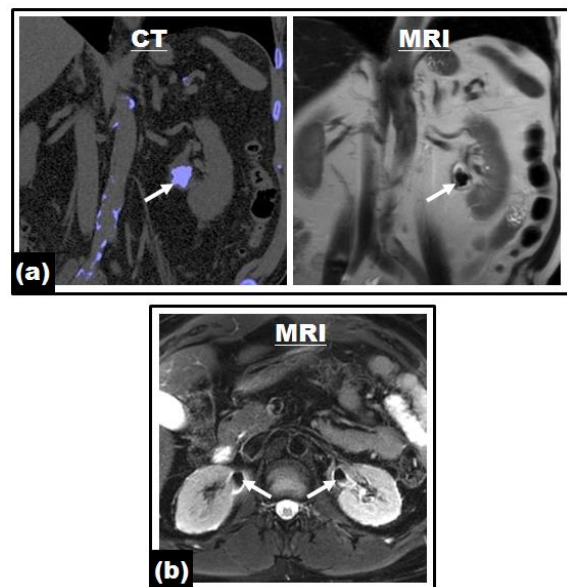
Conventional MRI images. (a) The MRI image on the right shows a good example of detecting kidney stone (arrow) compared to gold standard CT image on the left. (b) The signal voids are due to T2* artifact associated with concentrated gadolinium in the collecting system (arrows). These signal voids could be mistaken for stones.
